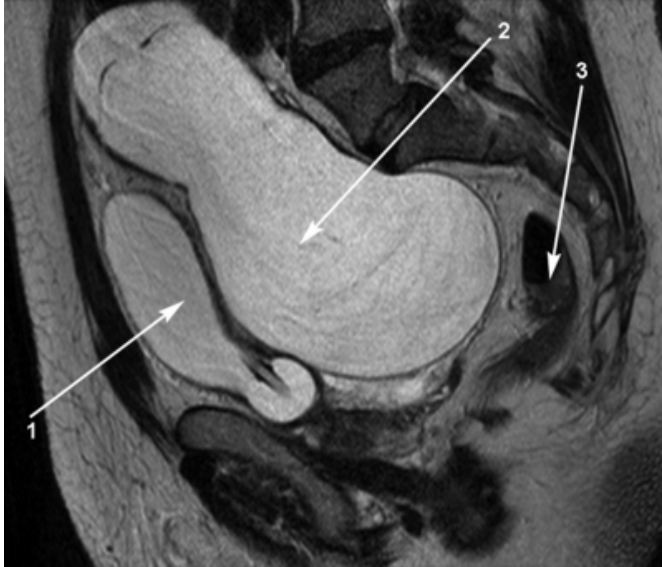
CT scan of the pelvis with the labels 1, 2 and 3 depicting the cyst (mucocele in this case), bladder and the caecum respectively.
